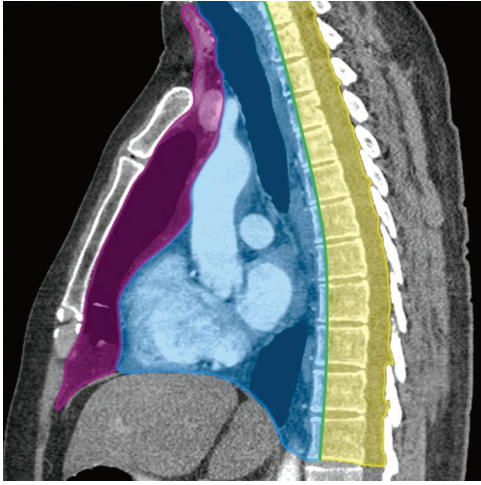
Mediastinal compartments as defined by the ITMIG classification¹ using multidetector CT image (Sagittal section). (1) Purple-prevascular compartment, (2) Blue-visceral compartment, (3) Yellow-paravertebral compartment, (4) Green line-visceral-paravertebral compartment boundary line
